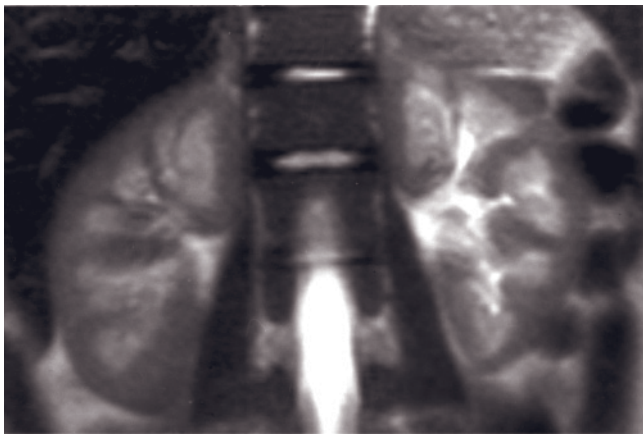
Sickle cell disease. Coronal (a) and transverse (b) T2-weighted SS-ETSE and T1-weighted precontrast (c) and 90-s
